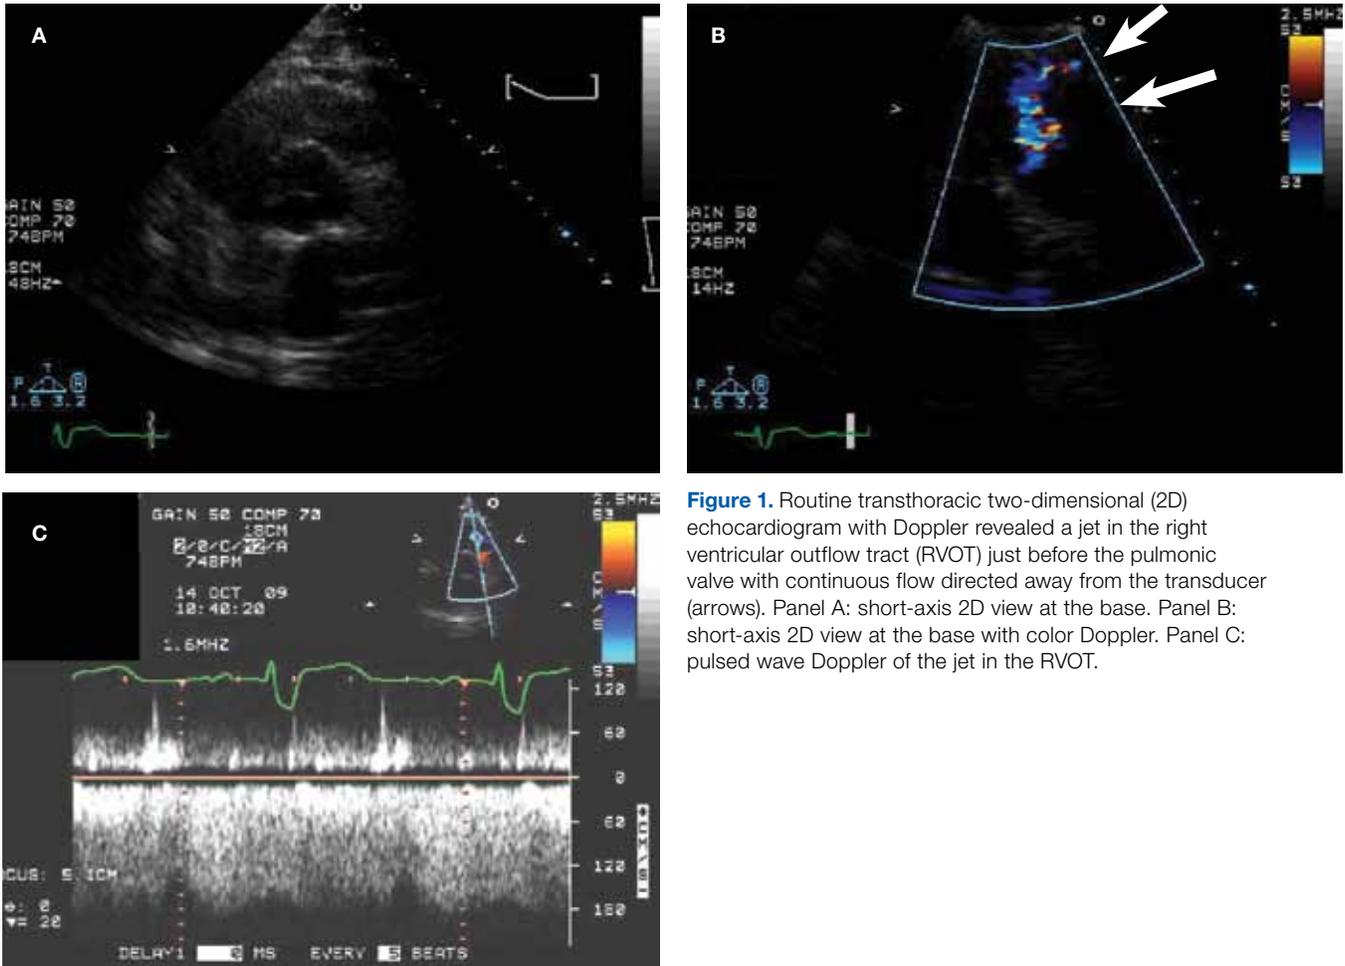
Routine transthoracic two-dimensional (2D) echocardiogram with Doppler revealed a jet in the right ventricular outflow tract (RVOT) just before the pulmonic valve with continuous flow directed away from the transducer (arrows). Panel A: short-axis 2D view at the base. Panel B: short-axis 2D view at the base with color Doppler. Panel C: pulsed wave Doppler of the jet in the RVOT.
